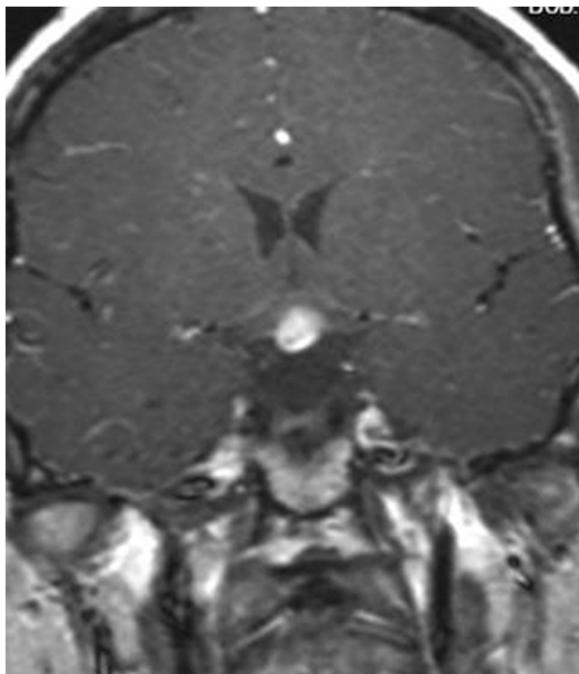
Coronal T1-weighted with contrast MRI showed ‘bright spot’ in tuber cinereum of the hypothalamus
